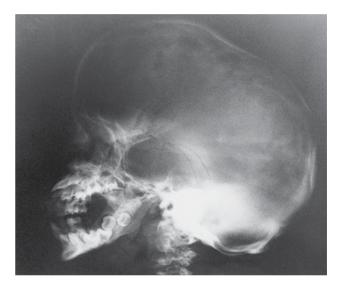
Roentgenographic appearance of the skull of DD. The very large cranium of both occipital and frontal areas was prominent. There was calcification of the choroid plexus of the left lateral ventricle. There was enormous enlargement of the sella and erosion of the clinoid processes. The mandibular rami were short, and there was increased angulation at the junction of the body and the varus, as well as flattening of the condyles.
